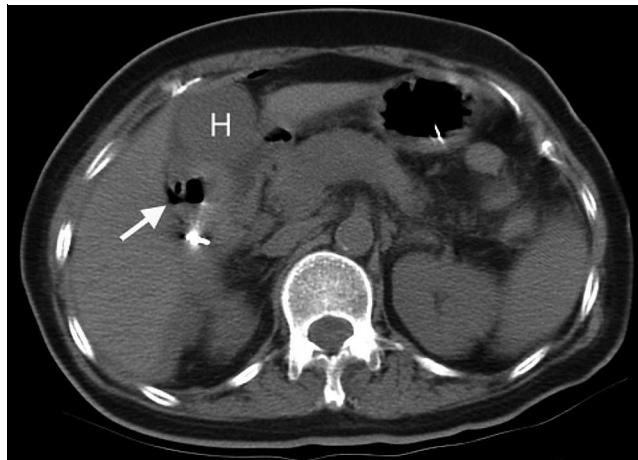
An abdominal computed tomography (CT) scan showing a large hematoma in the duodenum (H). The perforation site (indicated by the arrow) was located proximal to the ulcer, with the hemoclip still in place.
